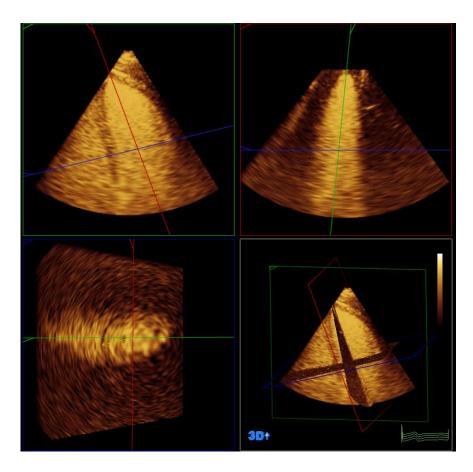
Snapshot of a three-dimensional contrast ultrasound image. Note the difficulty in identifying the mitral annulus. The volume rate for this image was 12Hz.
